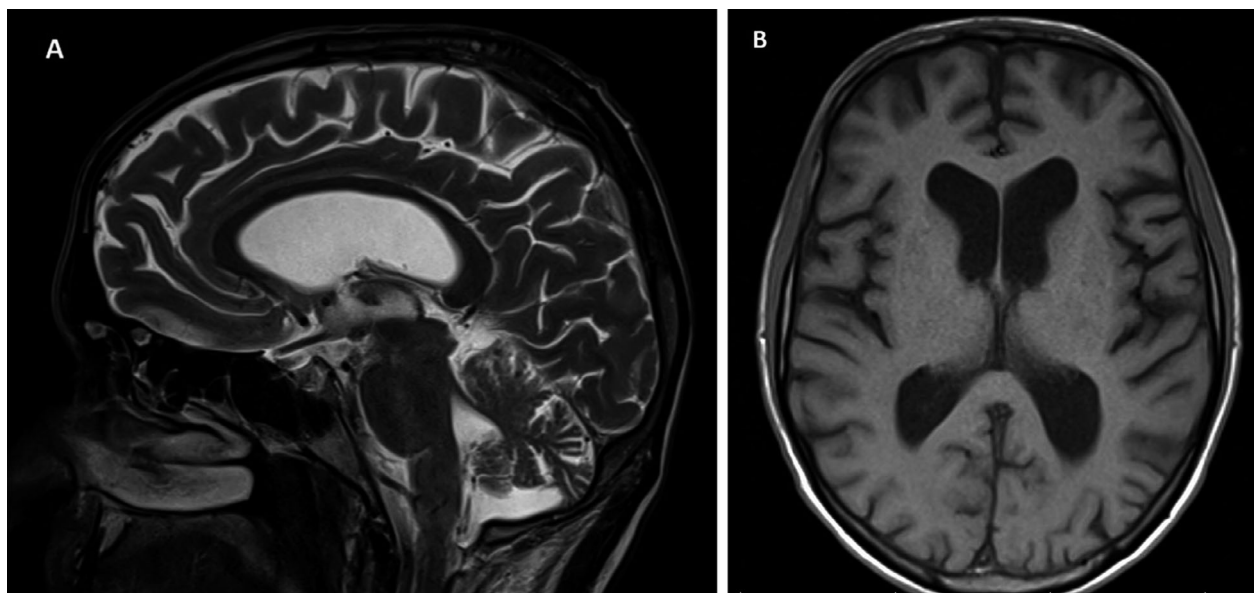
Brain MRI at the age of 45 years. (A) Sagittal T2 image and (B) axial T1 image showing supratentorial and infratentorial atrophy with enlarged lateral ventricles.
